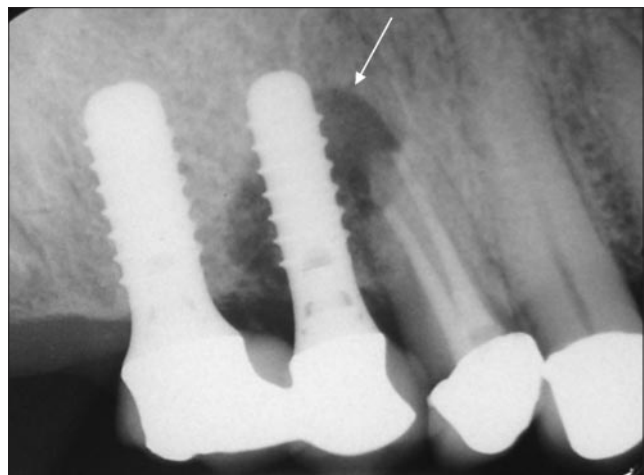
Radiographic appearance 5 months into maintenance therapy showing persistent and apparently expanding radiolucent lesion (arrow). Pain has not returned.
